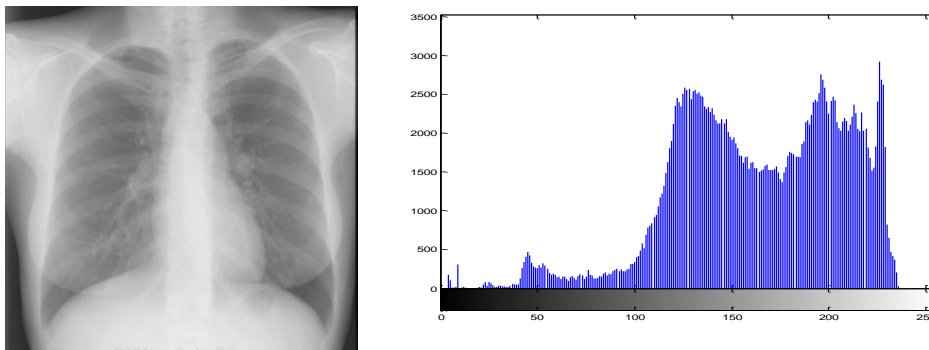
(a) Normal CXR's (b). Histogram of normal Chest X-ray
